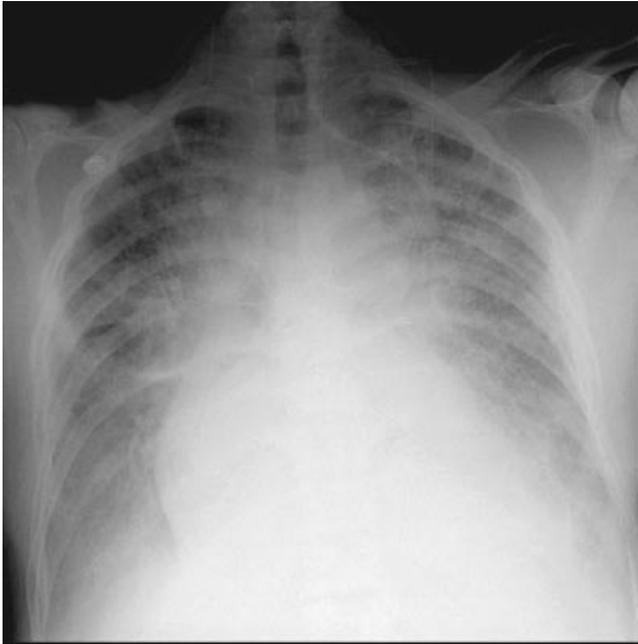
Chest X-ray demonstrating pulmonary oedema: cardiomegaly, alveolar shadowing, upper lobe diversion and blunting of the costophrenic angles.
